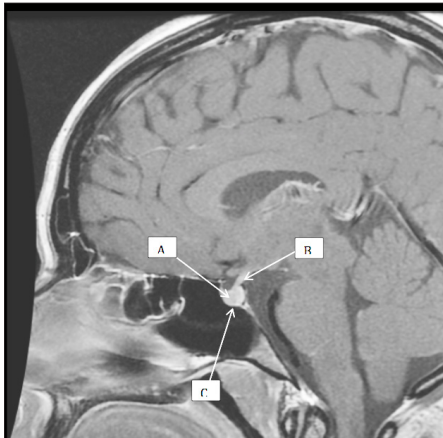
Sagittal section of normal pituitary gland on MRI scan.
